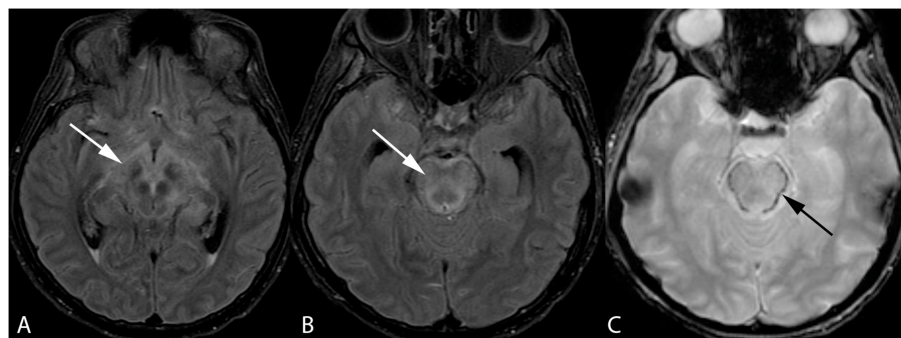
Forty-two-year-old woman with history of bone marrow transplantation. Axial FLAIR images (A,B) demonstrate central variant PRES with edema involving the midbrain with extension to the hypothalamus and optic tracts (arrow, A) and pons (arrow, B). Axial GRE image (C) shows petechial hemorrhage at the periphery of the pons (arrow).
